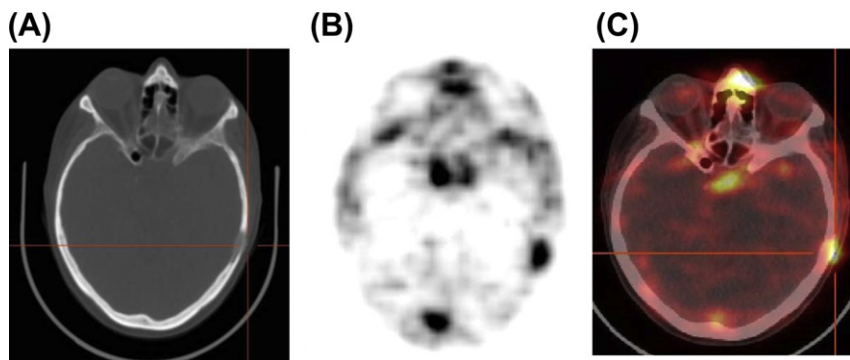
Axial images of lytic metastasis in left temporal bone in patient with MBC (with normal uptake in vasculature of $^{68}\text{Ga-F(ab')}_2\text{-trastuzumab}$). A) CT Scan; B) PET scan with $^{68}\text{Ga-F(ab')}_2\text{-trastuzumab}$; C) Fused CT-PET scan with $^{68}\text{Ga-F(ab')}_2\text{-trastuzumab}$. ^{68}Ga : Gallium 68, F (ab')₂: fragment antigen-binding 2, CT: computed tomography, PET: positron emission tomography. For color version of this figure, the reader is referred to the online version of this book.
